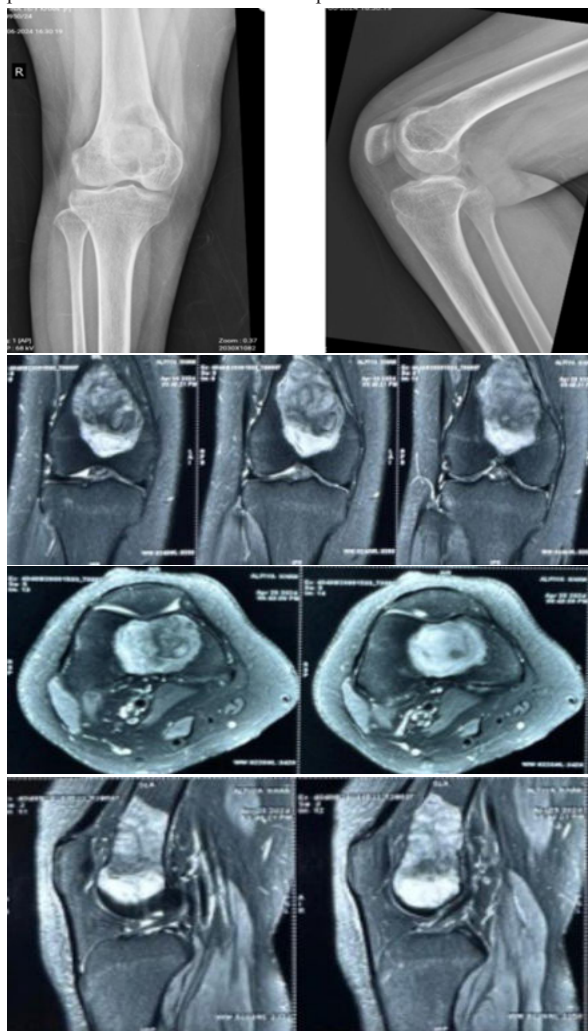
X-Rays and MRI of right knee preoperatively
